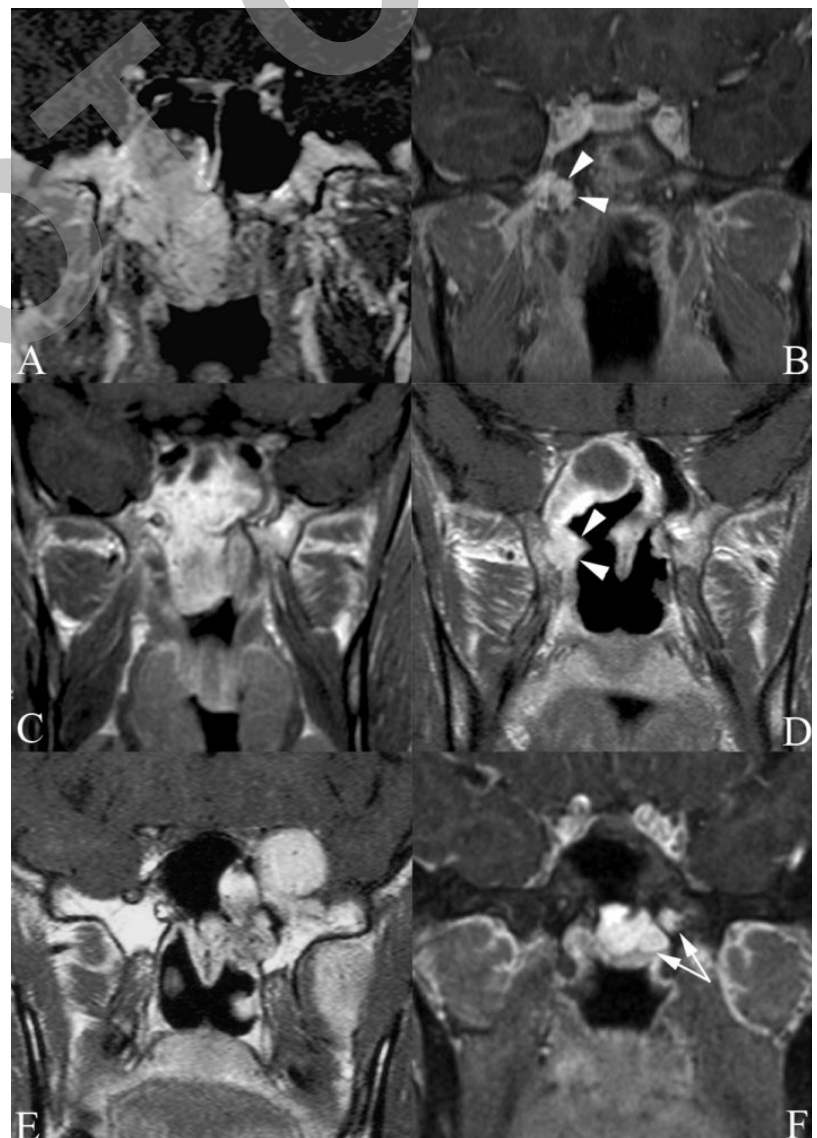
Suspected persistent juvenile angiofibromas (JAs). (A, C, and E) Pretreatment and (B, D, and F) follow-up contrast-enhanced magnetic resonance imaging (MRI) examinations are compared in three different patients; all displayed images were acquired in the coronal plane through the sphenoid bone. Suspected persistent JA is shown in panels B and D as a brightly enhancing nodule located in the right pterygoid root (arrowheads in panels B and D). The third lesion is composed of two nodules located in the basisphenoid and left pterygoid root, respectively (arrows in panel F).
